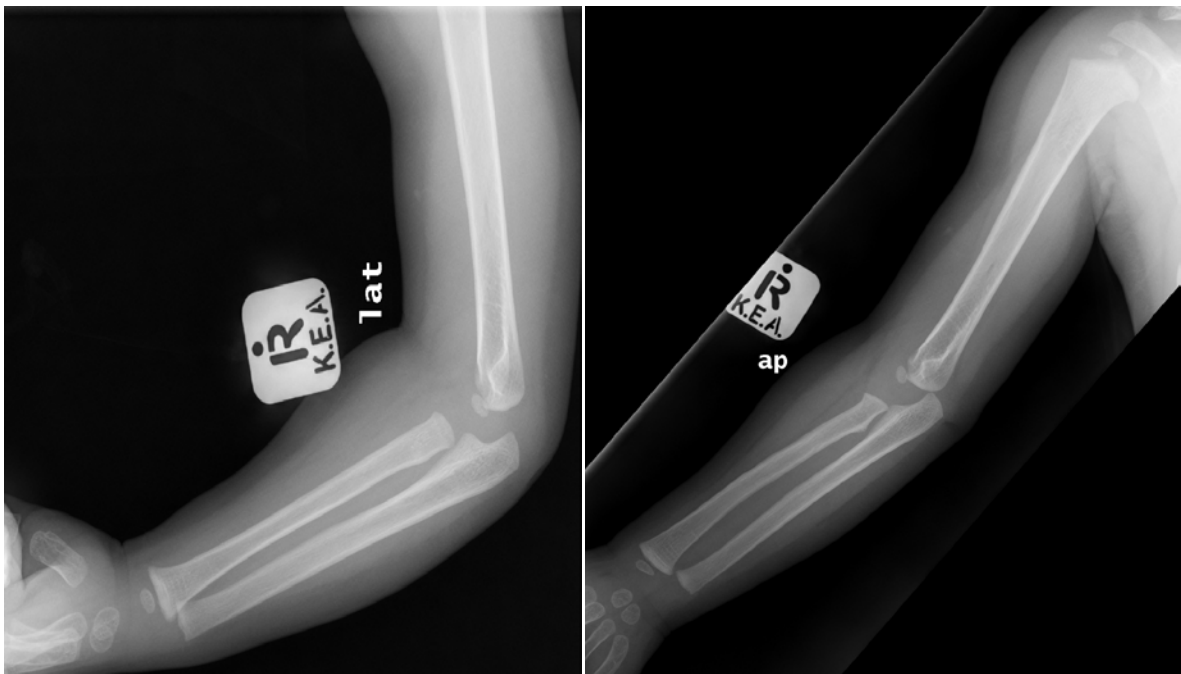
Lateral and AP radiograph of slide 8 (pre tutorial) and slide 13 (post tutorial)
